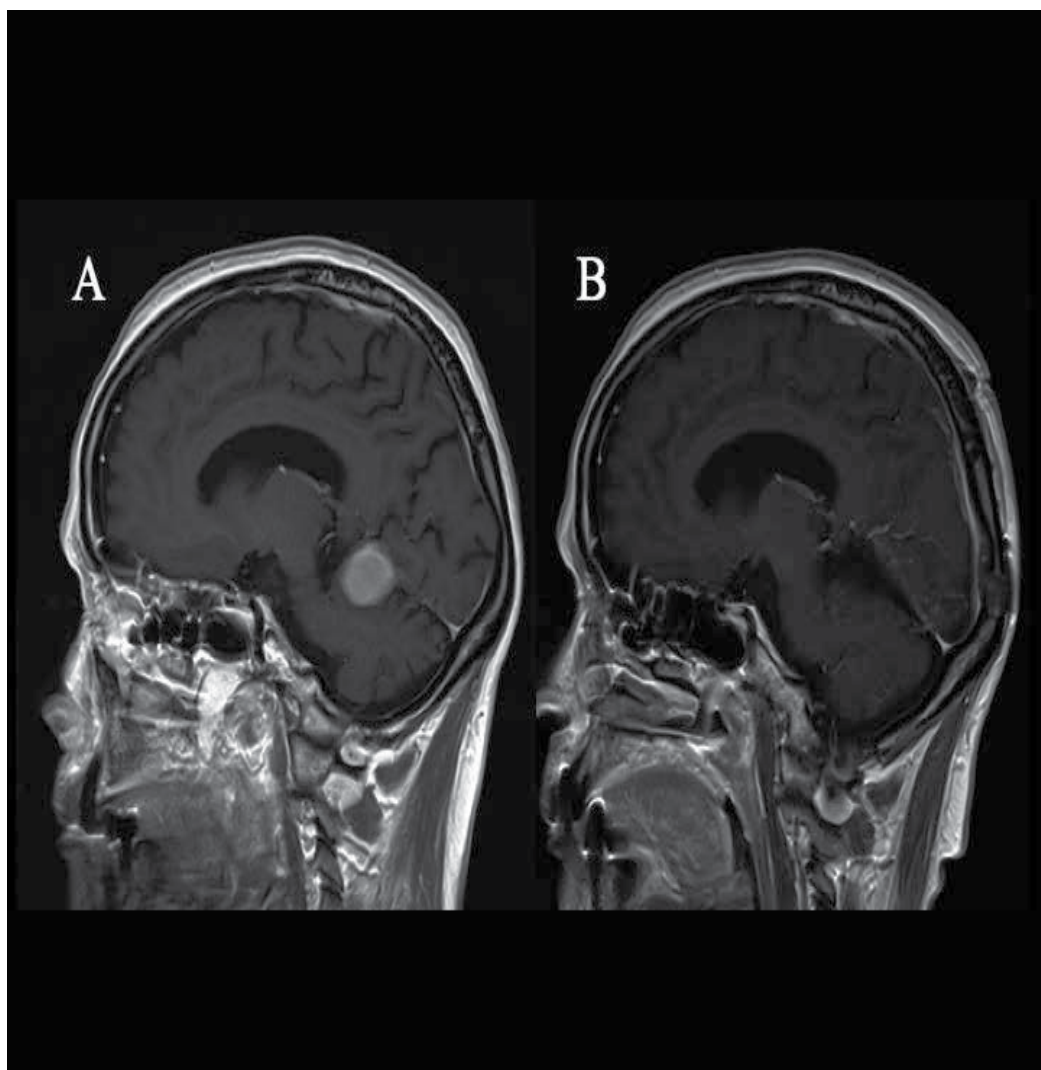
tentorial meningioma. (A: preoperative MRI revealing left tentorial meningioma. B: postoperative MRI demonstrating total removal of the tumour)
